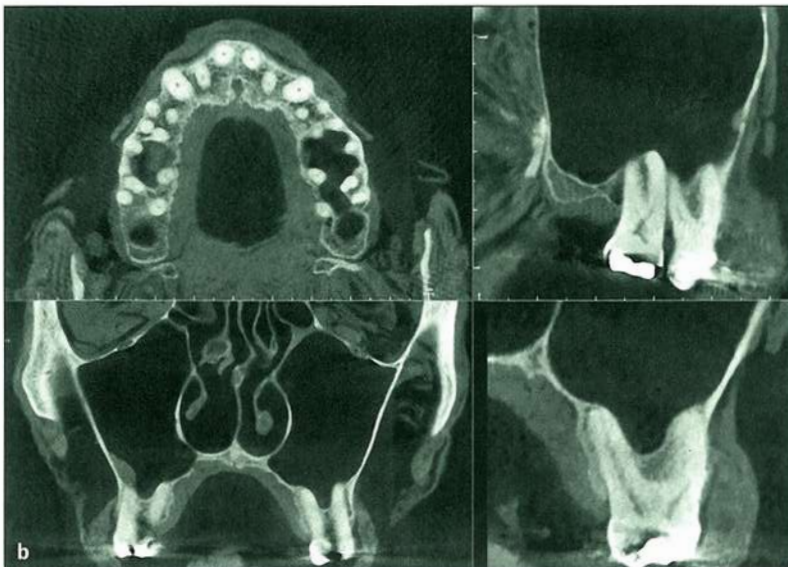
(a and b) Notice the small fenestrations into the floor of the sinus; in addition, one can appreciate the close proximity of the greater palatine nerve to the palatal roots of the maxillary second and third molars (blue arrows). The CBCT image is aligned in the coronal plane of the first molar, showing the mesial buccal and palatal root.
